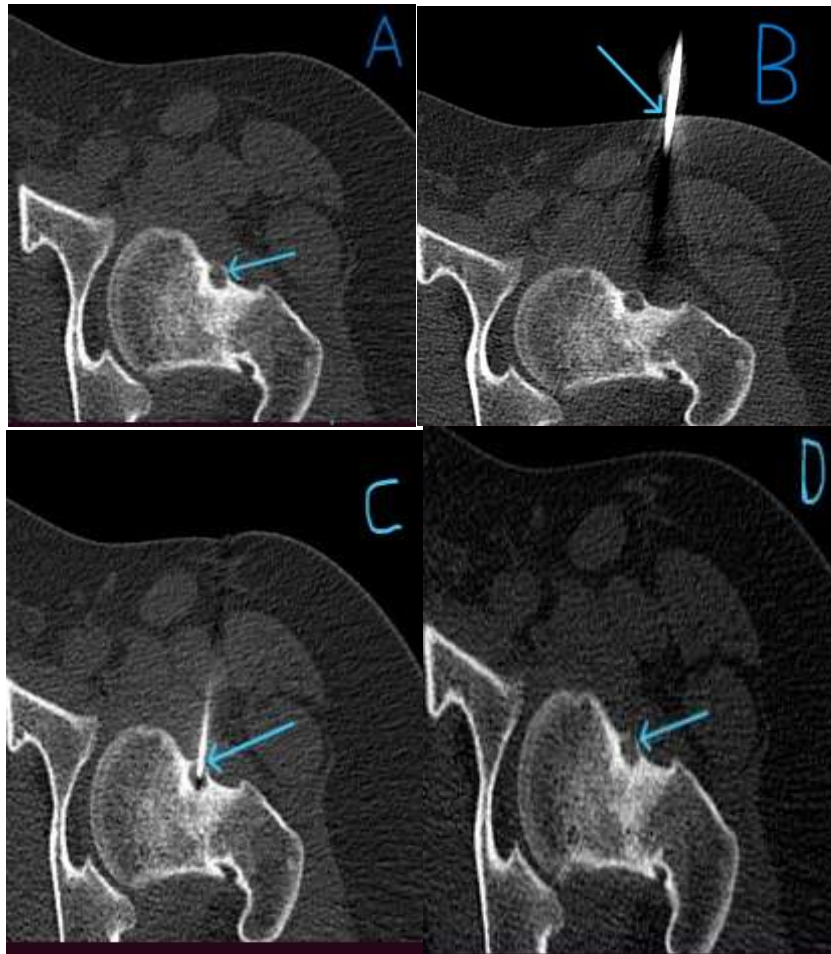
A) Pre-procedure axial CT image shows the hypodense nidus at the anterior cortex of the neck of the left femur surrounded by sclerotic bone reaction. B) During the procedure, axial CT image shows the bone needle entrance from the skin. C) During the procedure, axial CT image shows the tip of the RF electrode in the nidus. D) The immediately post-procedure axial CT image shows a good ablation zone with no complications at the ablation site.
